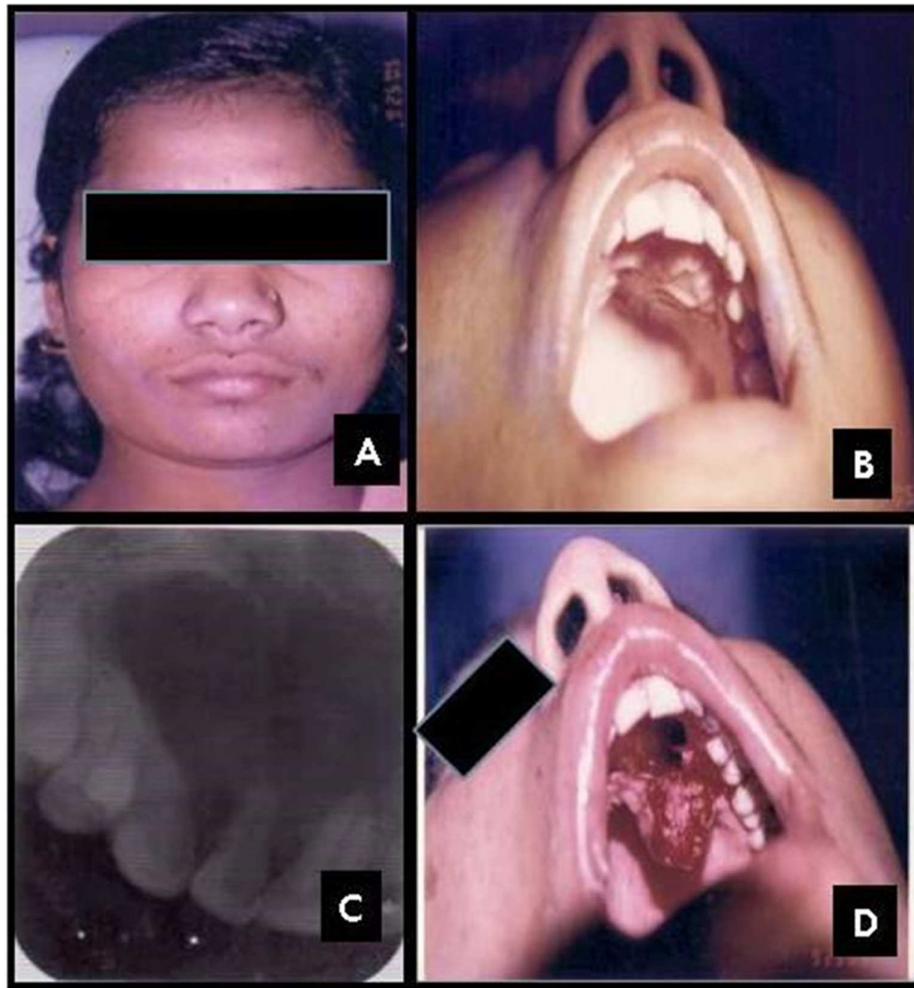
A- Extraoral view. B- Intraoral view. C- Intraoral periapical radio- graph. D- Surgical view.
